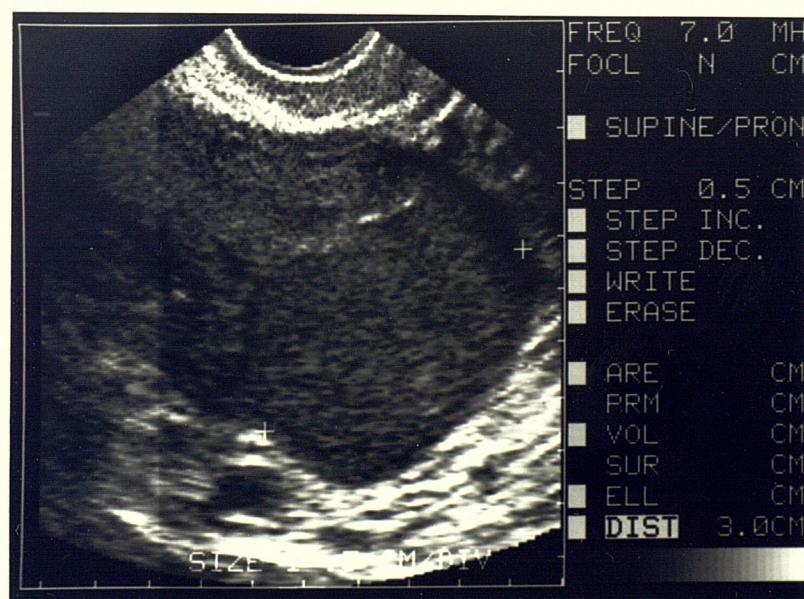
Transvaginal ultrasound of endometrioma
